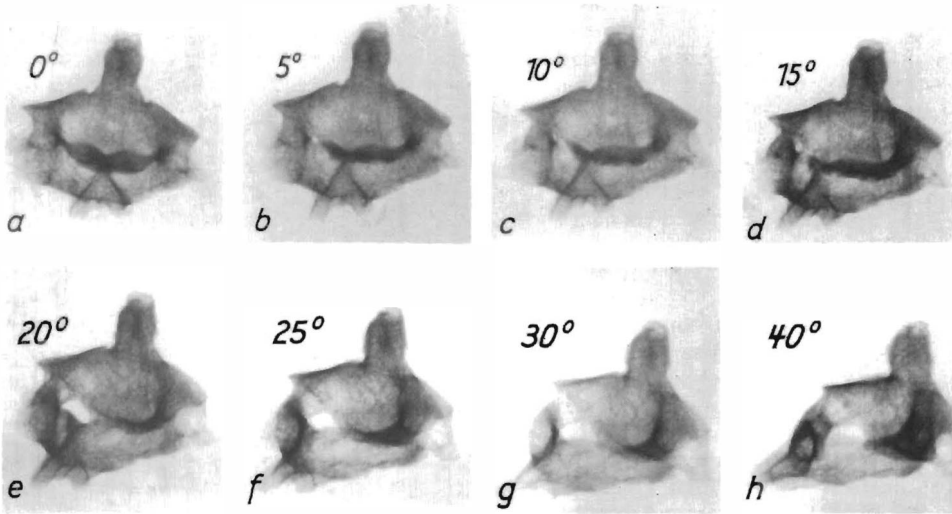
Anteroposterior X-rays of an isolated axis: (a) in neutral position and (b–h) in rotation from 5 to 40 degrees; the pictures are useful for grading rotation
